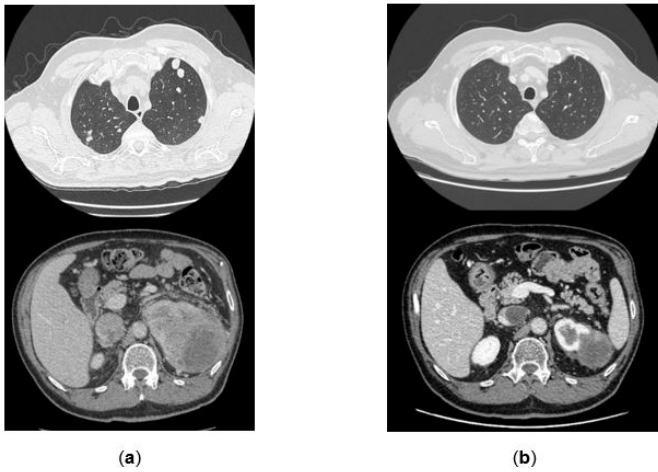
Case 1 Axial CT scan of lung metastases, mediastinal nodes and primitive renal mass before; (a) and after (b) ICIs/TKI combination treatment.
